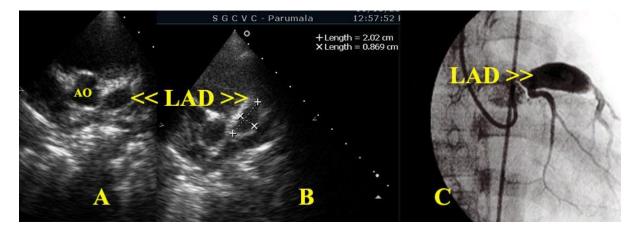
A-C: Giant coronary artery aneurysm (Z score >10). A-B; standard short axis view modified at the aortic valve level (AO) in 2-D Echocardiogram; Proximal segment of left anterior descending artery (LAD) with giant aneurysm marked (<<LAD>>) measuring 20x8.6mm. C; Coronary artery angiogram same case showed fusiform giant aneurysm of the proximal segment of LAD with normal left main and circumflex artery.
